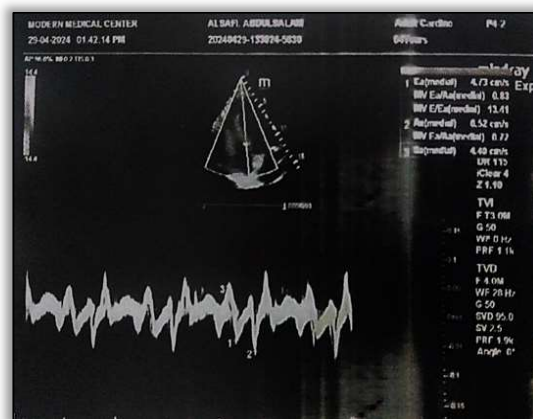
Velocity Values Derived from Tissue Doppler Measurements of Myocardial Motion in the Left Ventricle, Specifically at The Basal (Septal) Mitral Annulus.*
